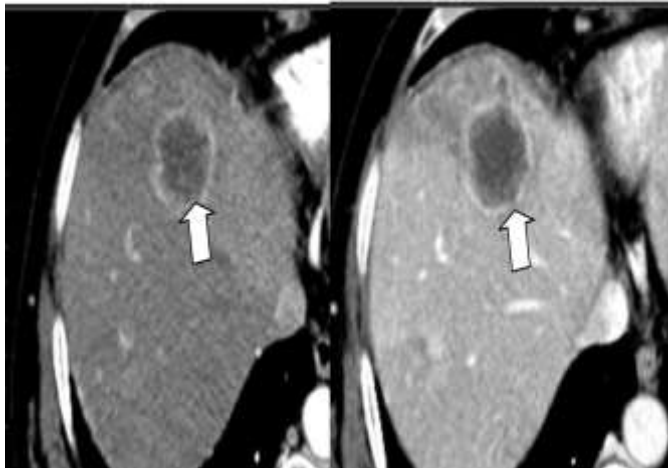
Complete ring pattern of Metastasis. Transverse arterial phase CT scan of metastases from a sigmoid colon primary depicts ring enhancement (arrows) with well-defined smooth inner margins surrounding central regions of low attenuation.
